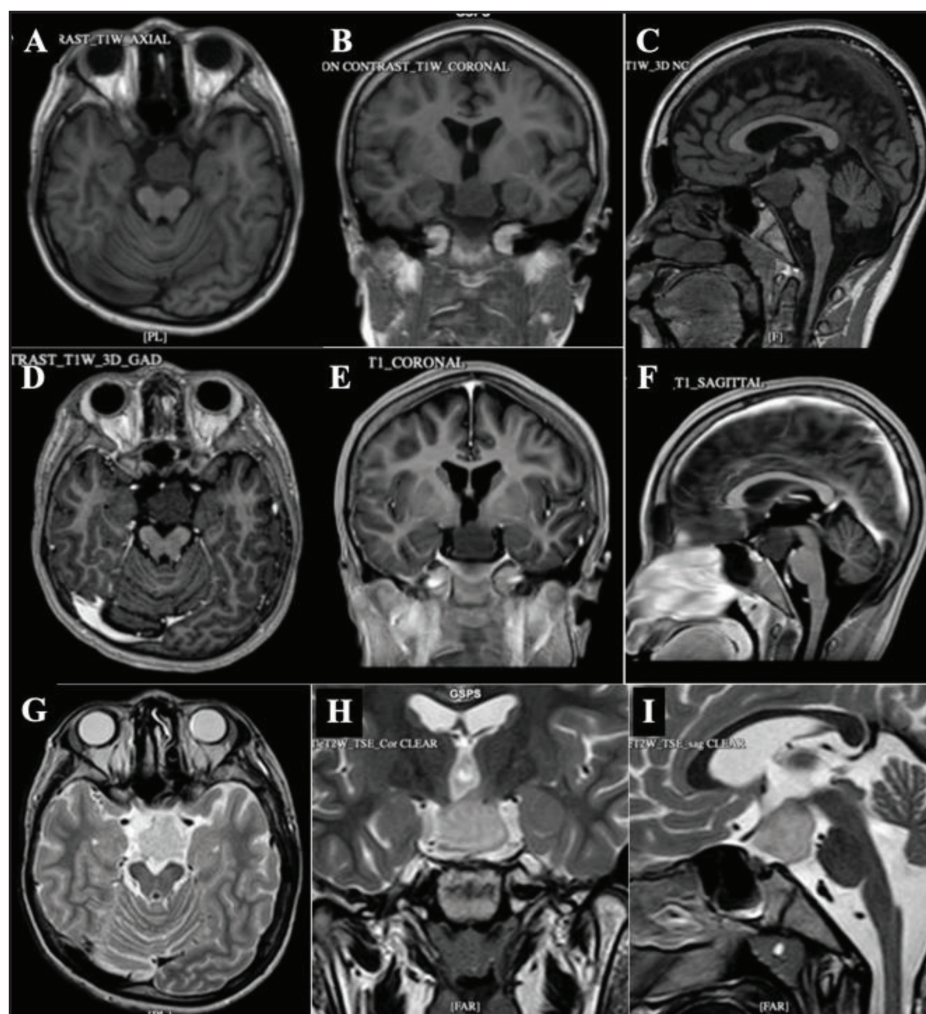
Pre-treatment MRI of Case 3. T1-weighted MRI without contrast in axial (A), coronal (B), and sagittal (C) views; T1-weighted MRI with contrast in axial (D), coronal (E), and sagittal (F) views; and T2-weighted MRI in axial (G), coronal (H), and sagittal (I) views. MRI demonstrates a sessile HH (Delalande type IIA) measuring approximately $2.2 \times 2.3 \times 2.4$ cm. The lesion occupies the suprasellar and interpeduncular cisterns and abuts the tuber cinereum, mammillary bodies, optic tracts, and cerebral peduncles.
